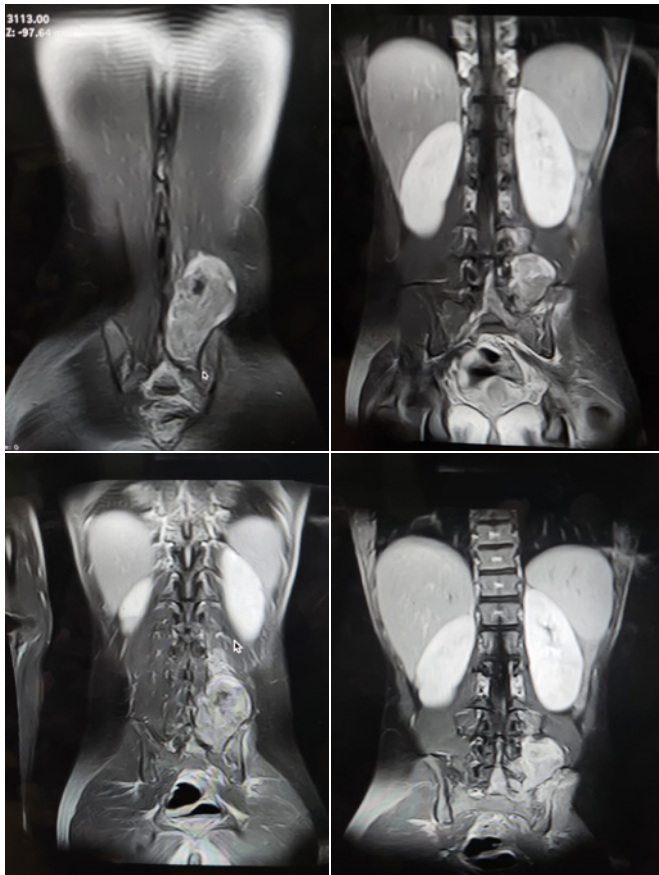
Coronal MRI images T2 sequence showed infiltration in the left paraspinal muscle at the level of L3/L4 vertebral bodies which was infiltrating into the left exit foramina and left psoas muscle and posterior abdominal muscle forming a large mass with central area of low signal extending into the left exit foramina at the level of L4/5 and in the spinal canal, continuing up to the sacral region of about the level of S3.
